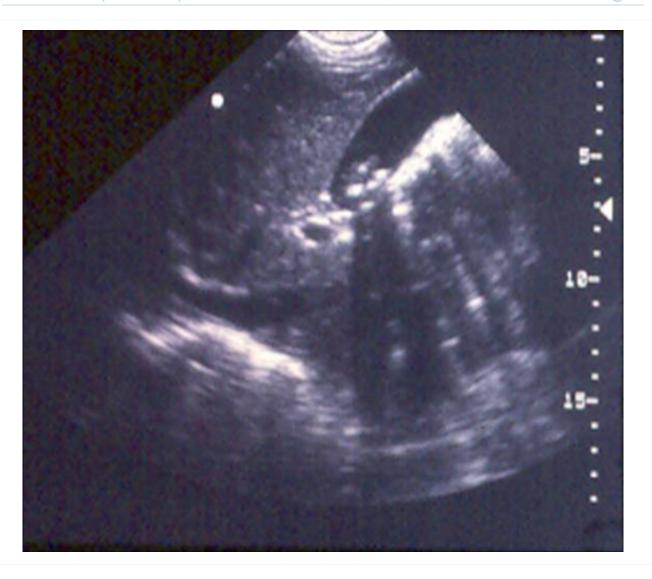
Gallbladder ultrasound demonstrating cholelithiasis with characteristic shadowing
